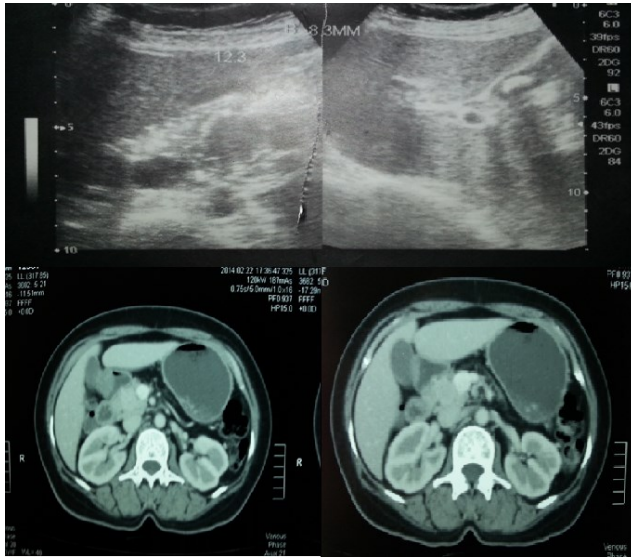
Patient's Abdominal USG (above) and abdominal CT scan (below)
